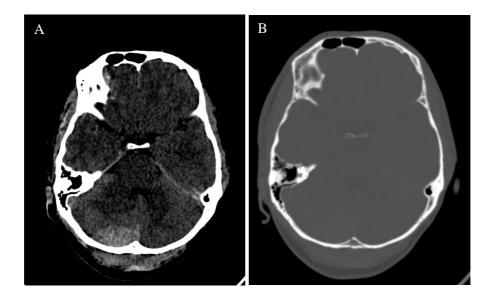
CT Brain plain study in a 45 years old male patient with history of Road traffic accident showing Extradural haemorrhage in right occipital region (A) and fracture of right occipital bone (B)
